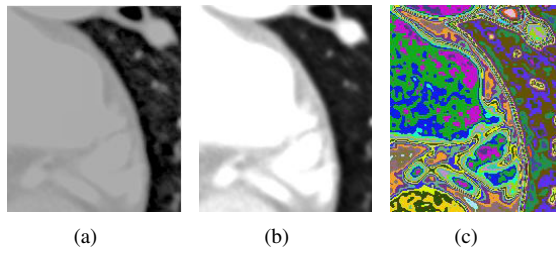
An example of image enhancement for an axis LAA CT slice. The details of the dark area can be effectively reflected. (a) Original. (b) Multiscale retinex. (c) Multi-channel.
